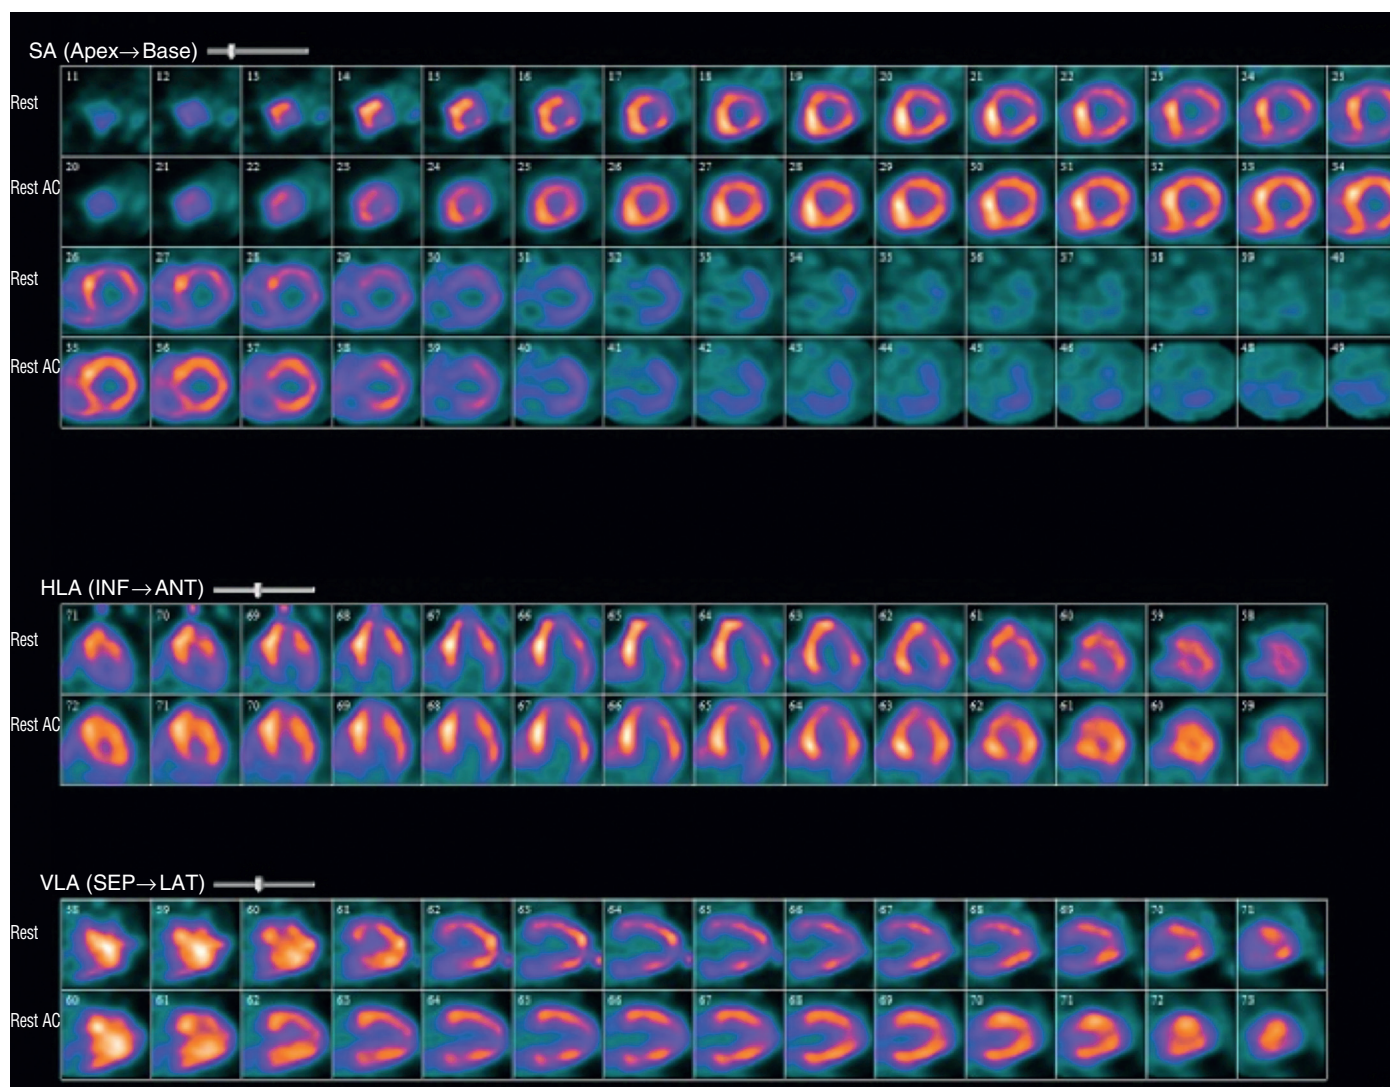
FIGURE e65-5 Technetium pyrophosphate scan in a patient with senile systemic amyloidosis (SSA). Paired sets of images with nonattenuation-corrected images labeled “rest” and corresponding CT-based attenuation-corrected images labeled “rest AC.” An 81-year-old man was evaluated for heart failure and marked wall thickening on his echocardiogram; he did not have any evidence of a plasma cell dyscrasia. The heart avidly took up the isotope (a normal heart exhibits no uptake). This is highly suggestive of TTR amyloidosis, later proved by biopsy. Genetic testing for a *TTR* mutation was negative and SSA was confirmed. AC = attenuation corrected; HLA = horizontal long axis; SA = short axis; VLA = vertical long axis. (Courtesy Dr. Sharmila Dorbala, Brigham and Women’s Hospital, Boston.)
